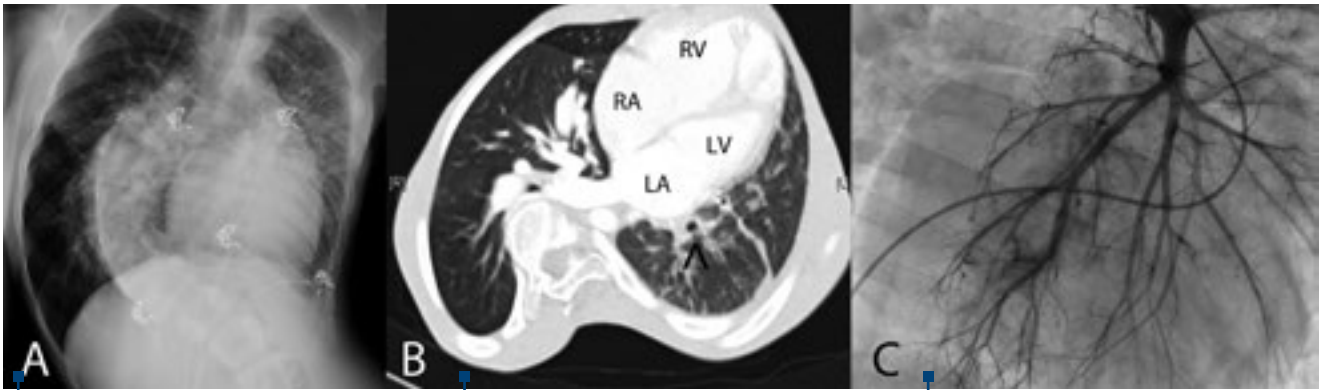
Chest radiography showing pulmonary venous congestion, interstitial lesions and pleural changes in the left lung with associated severe scoliosis.
